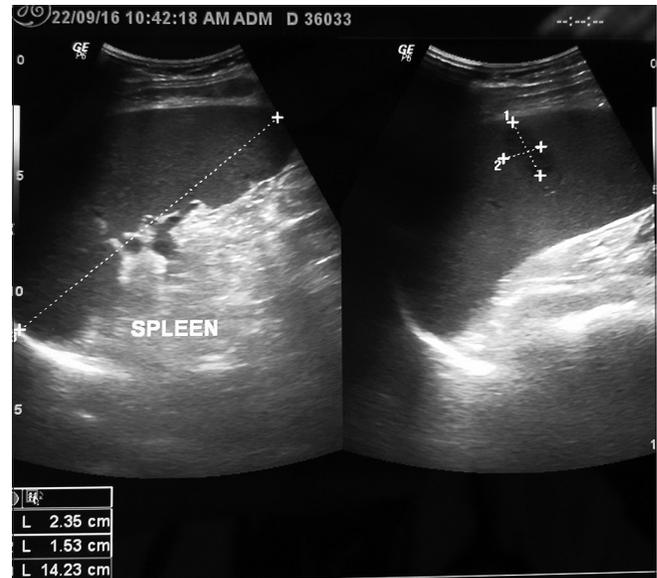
Ultrasonography: Hypoechoic lesion 13 mm x 14 mm peripherally at midpole
